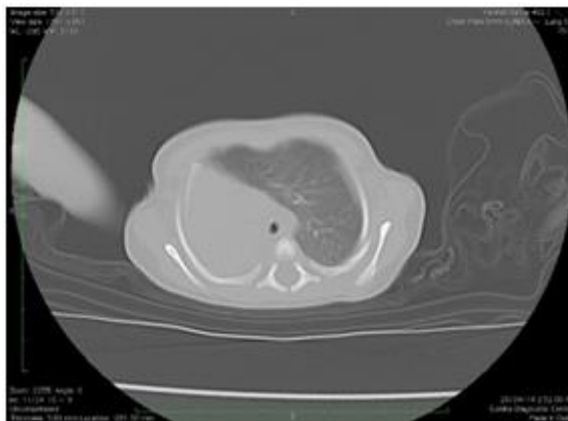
CT Axial Image shows compensatory hyperinflation of left lung which is crossing the midline.
